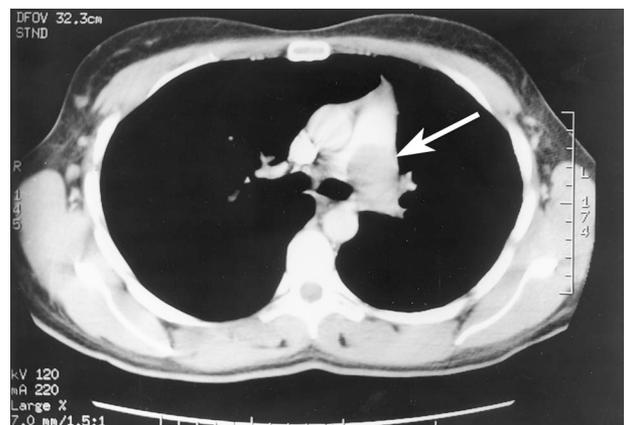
Chest CT scan with IV contrast showing a filling defect (arrow) in the left main pulmonary artery.
